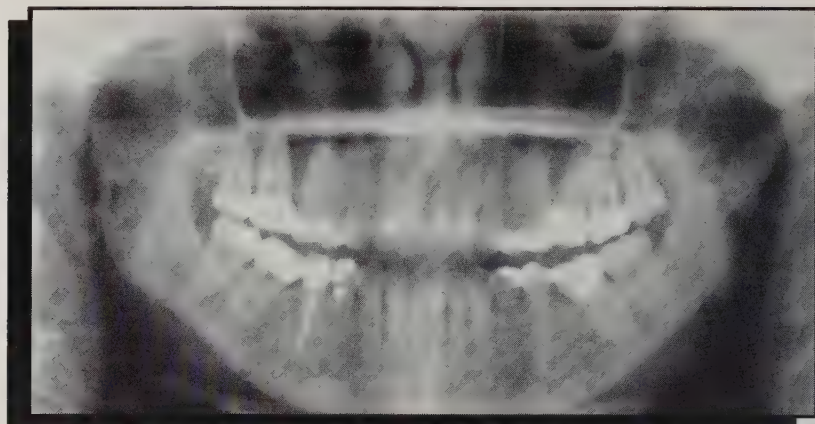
Panoramic radiograph showing advanced degeneration of both proximal segments and mandibular condyles.
